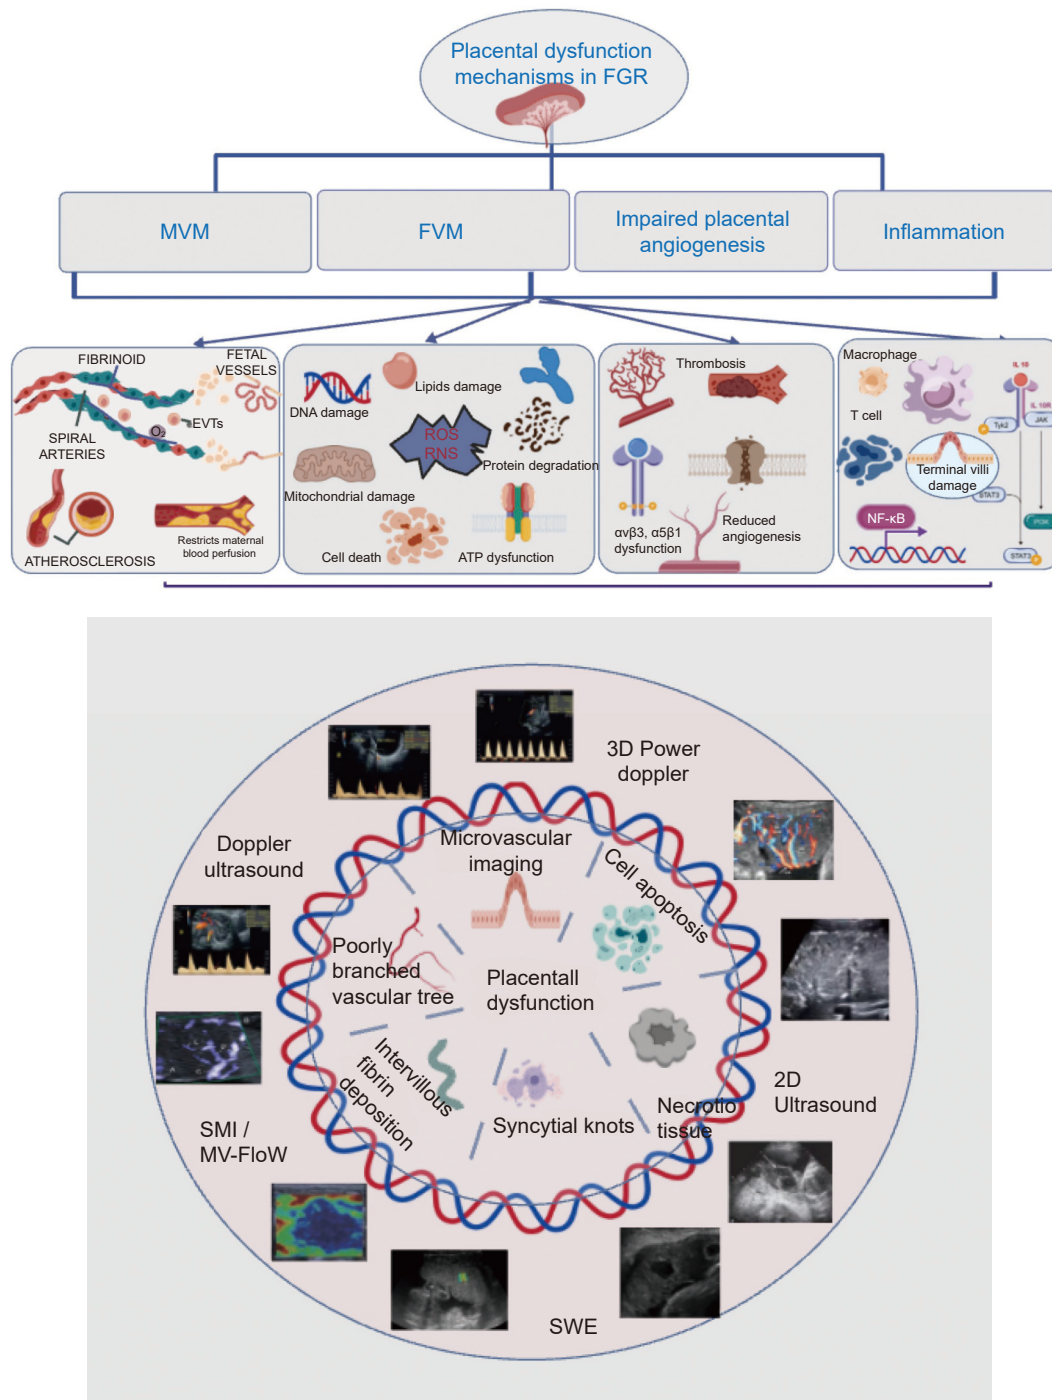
Correlation between ultrasound indicators and etiological mechanisms in placental dysfunction.
